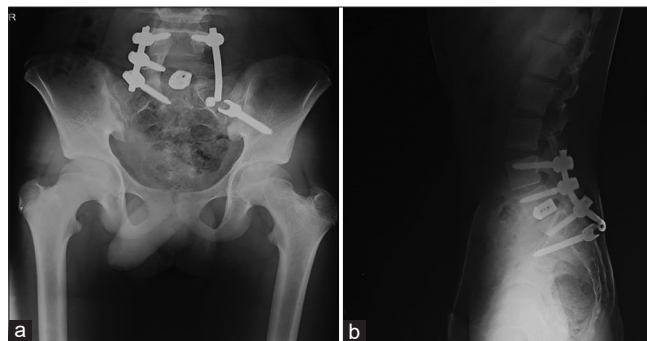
The preoperative antero-posterior and lateral radiograph of the spine. (a) The antero-posterior radiograph demonstrates an enlarged lytic lesion with predominant involvement of the left side of sacrum and lower lumbar vertebrae.
